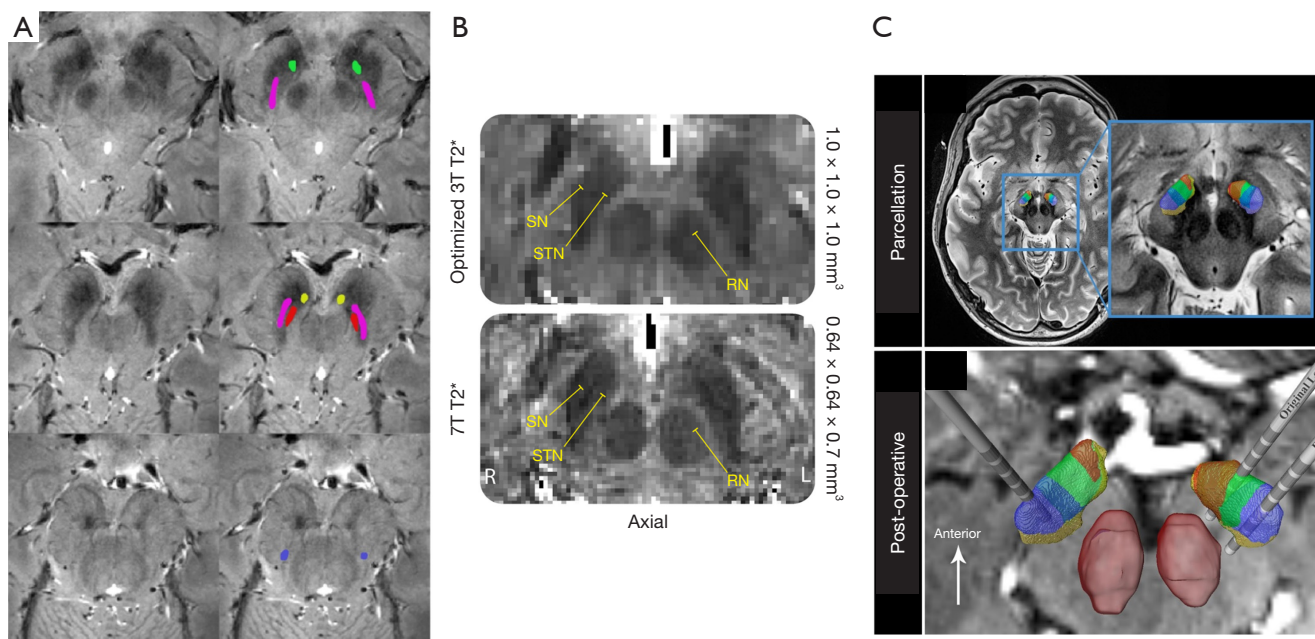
Results from recent clinical studies applying 7T MRI in Parkinson's disease. (A) T2*-weighted 7T MRI visualisation of nigrosomes 1–5 in a 60-year-old Parkinson's disease patient from the rostral, medial and caudal substantia nigra (top, middle, bottom rows) with N1 = purple, N2 = yellow, N3 = blue, N4 = red and N5 = green. (B) Comparison of 3T and 7T MRI T2*-weighted images, showing superior resolution and visualisation of substructures at 7T. (C) DBS implantation in a 52-year-old with Parkinson's disease showing that sub-parcellation of the subthalamic nucleus (multi-coloured) and red nucleus (red) could assist in repositioning of original (incorrect) lead location to the sensorimotor region (blue). Subfigures (A–C) were adapted from their original published versions (cropped), and were originally published under the Creative Commons Attribution 4.0 International (CC BY) license. Subfigure (A) was adapted from Fig. 1 by Schwarz *et al.* 2018 (22), subfigure (B) was adapted from Fig. 2 by Isaacs *et al.* 2020 (28), and subfigure (C) was adapted from Fig. 1 by Schrock *et al.* 2021 (29). 7T, 7 Tesla; 3T, 3 Tesla; STN, subthalamic nucleus; SN, substantia nigra; RN, red nucleus; MRI, magnetic resonance imaging; DBS, deep-brain stimulation.
